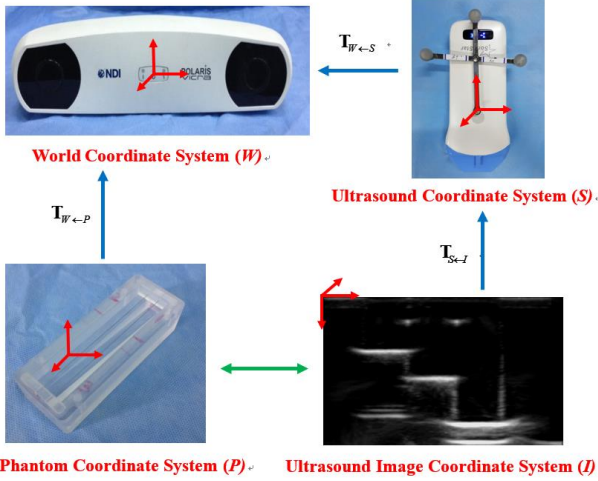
Transformations during ultrasound calibration
